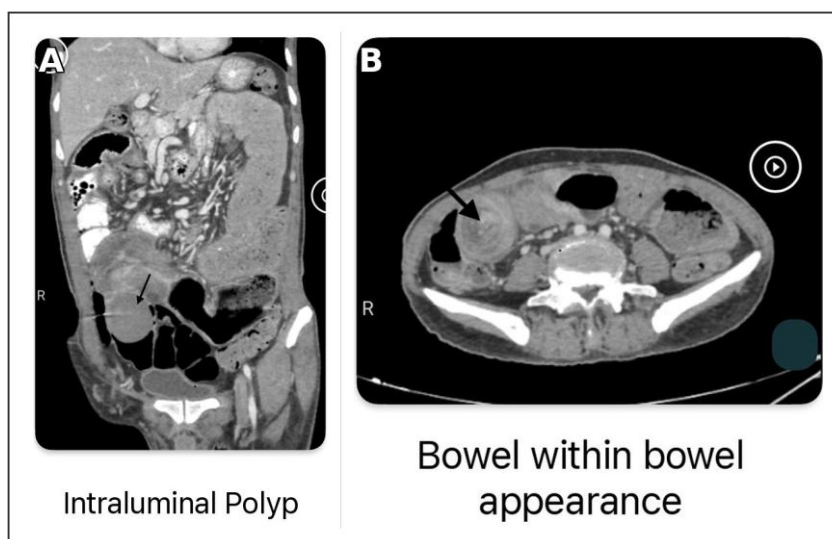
CT scan showing (A) intraluminal polyp acting as lead point and (B) characteristic bowel-within-bowel appearance of ileo-ileal intussusception.
